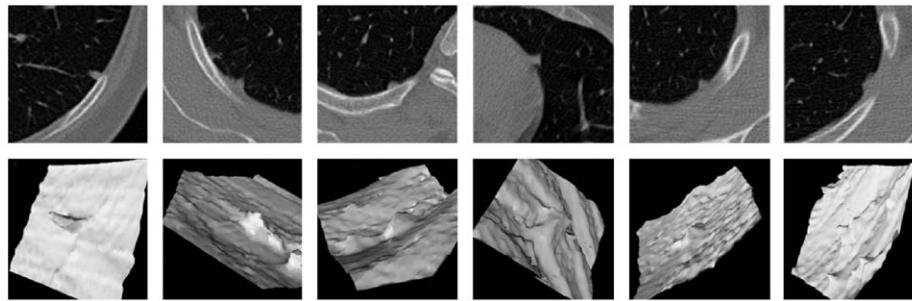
Examples of pleural nodules: nodule appearance in 2D CT slices (top) and the corresponding shaded surface display representations (bottom).
